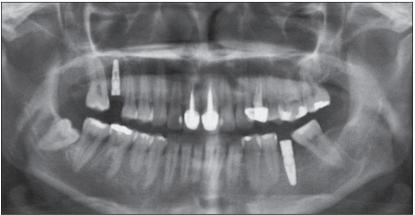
(above) Six-month postoperative panoramic radiograph showed a stable bone graft.
